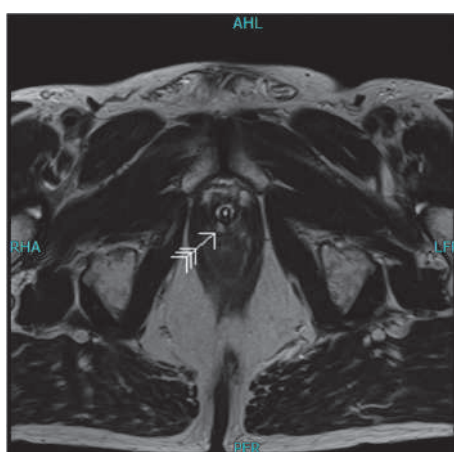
(a) and 1(b) MRI views demonstrated different location and amount of bulking agent on 3.5 mm slides. Both patients had 5 injections with bulking agent. The urethra can be recognized by the transurethral catheter.
